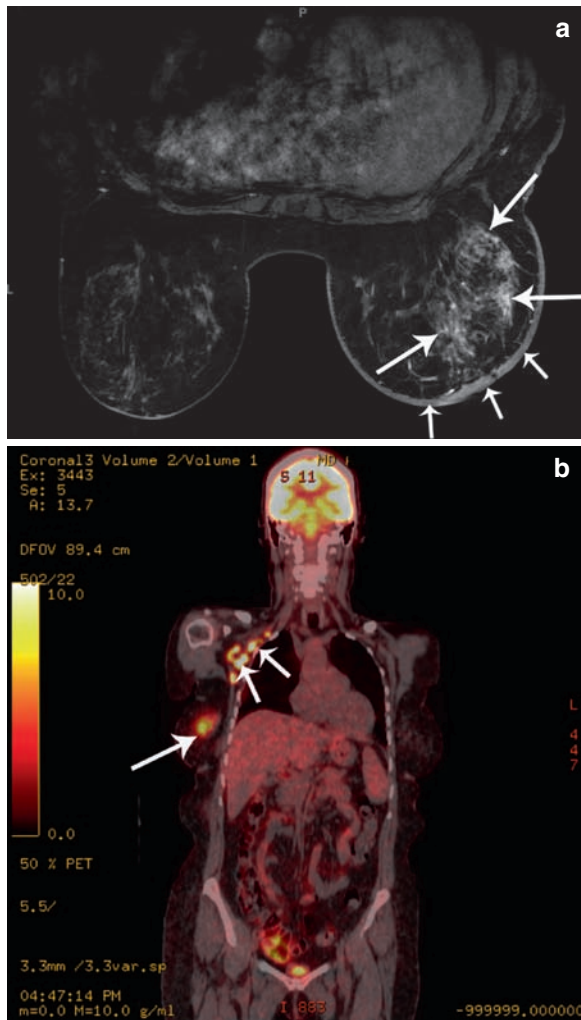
Contrast enhanced T1-weighted fat-saturated axial image shows asymmetric non mass-like enhancement in the right breast (*long arrows*), with marked global skin thickening (*short arrows*) (a). Coronal PET/CT in a different plane shows hypermetabolic right breast mass (*long arrows*), and right subpectoral adenopathy (*short arrows*) (b)
